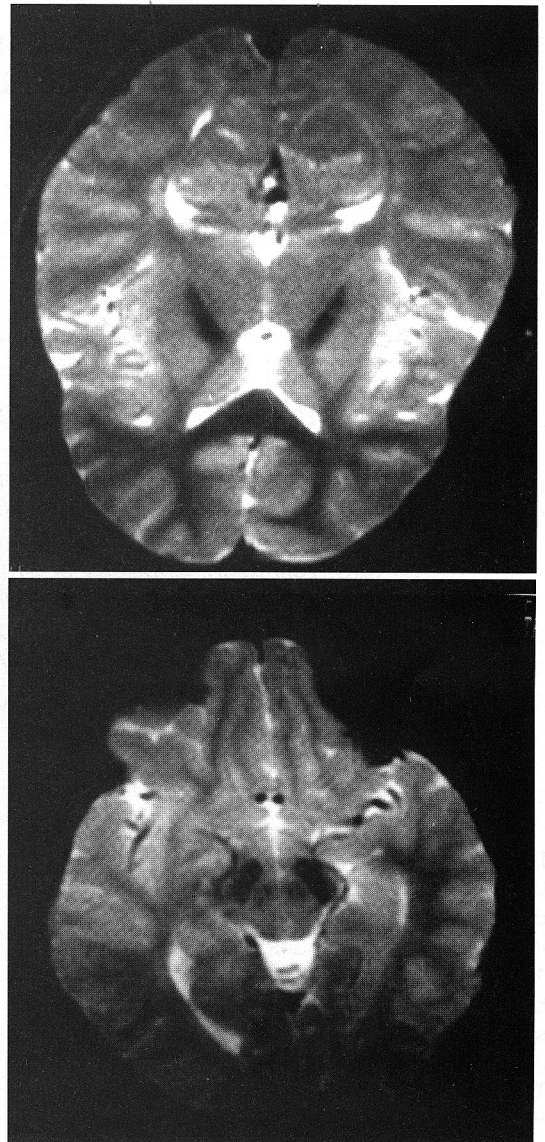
Magnetic resonance scan T2-weighted images (2.0 T) of patient 2 discloses bilateral markedly decreased signal intensities in the globus pallidus and the substantia nigra.
